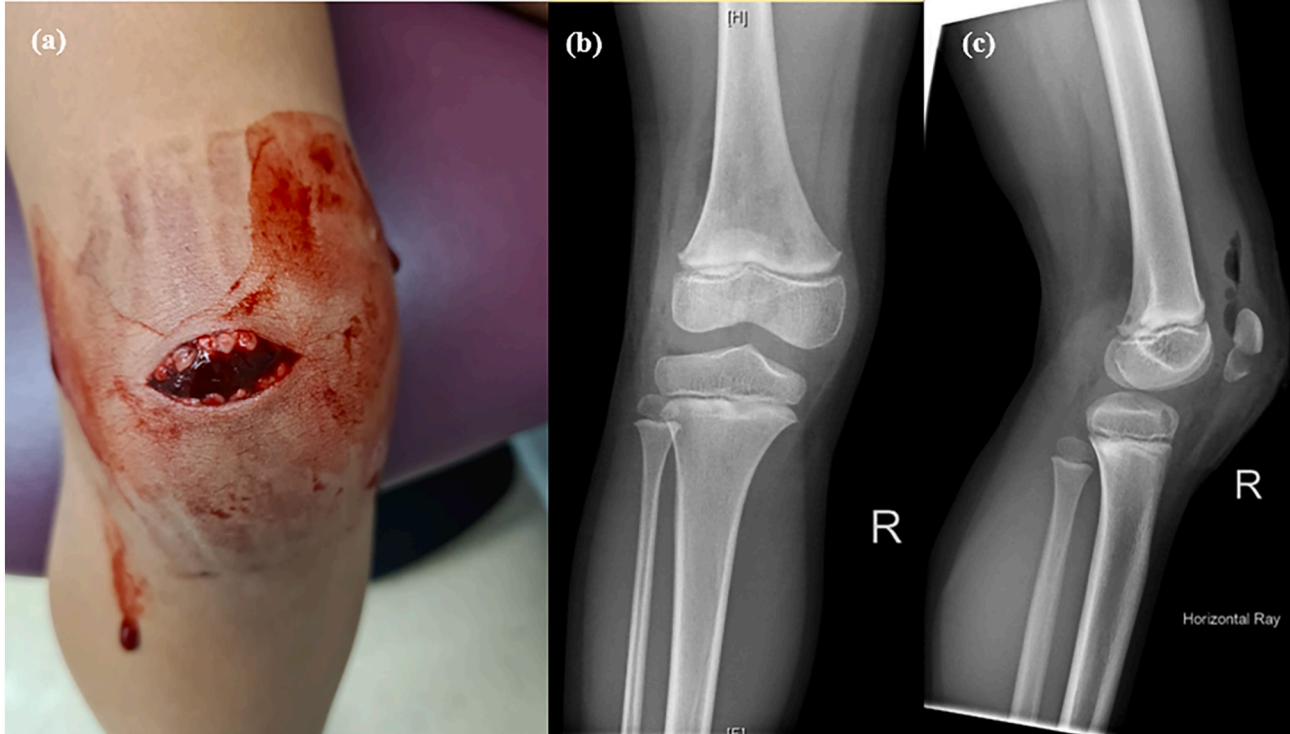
(a) Clinical photo of knee demonstrating transverse laceration prepatellar region. (b) Anteroposterior and (c) lateral radiographs of the right knee demonstrating an open transverse patella fracture with gas in the knee joint.
